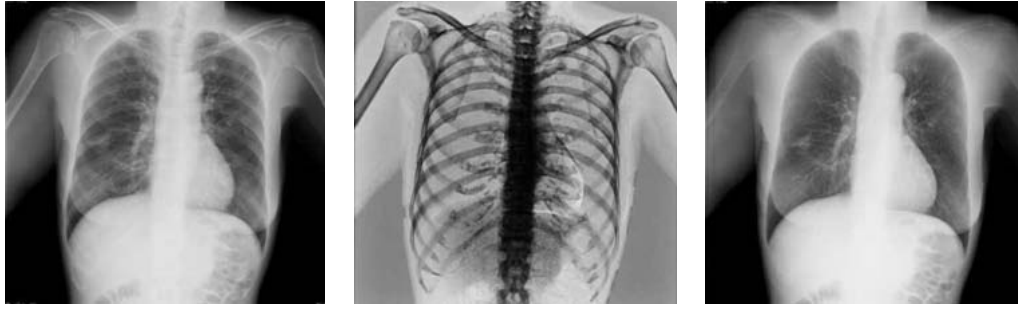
Example images from dual-energy subtraction, left: standard x-ray image, middle: bone image, right: soft tissue image (Uemura et al., 2005).
